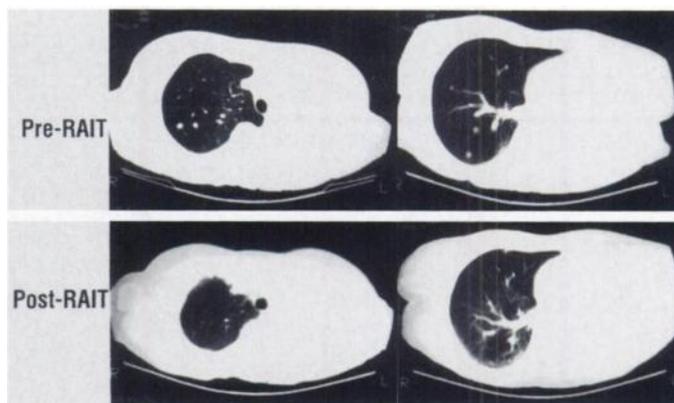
CT scans of the chest 2 days before (top) and approximately 2 mo after a second RAIT (bottom) with 68.1 mCi ^{131}I NP-4 F(ab')₂ in Patient 775. Scans are taken at the level of the aortic arch and right lower lobe artery show the disappearance of two small nodules in the right upper lobe and two other nodules in the right lower lobe. No significant change was seen in at least two other nodules.
